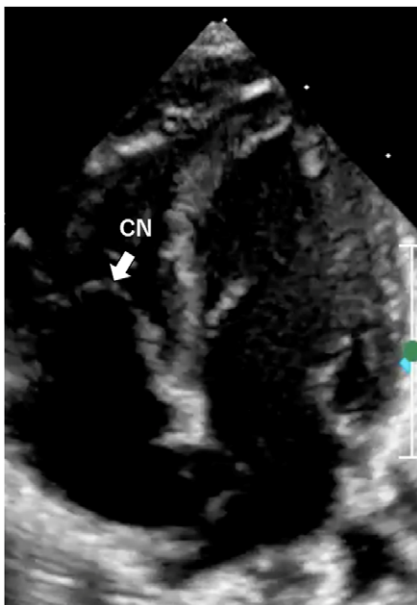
Apical four chambers view in diastole shows the Chiari network protruded into the right ventricle.
